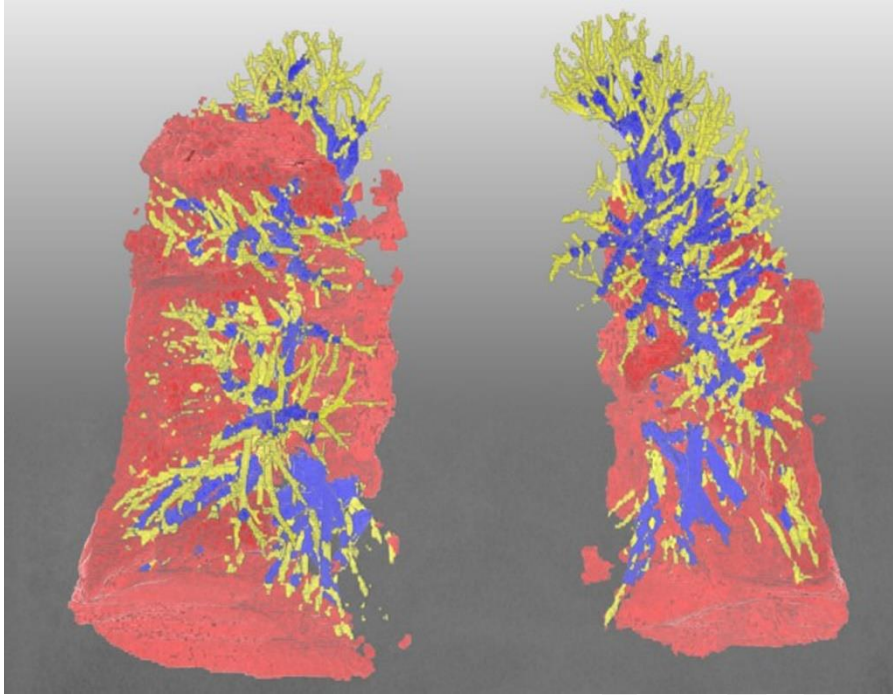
Chest CT from an 88-year-old woman with the Delta variant.
